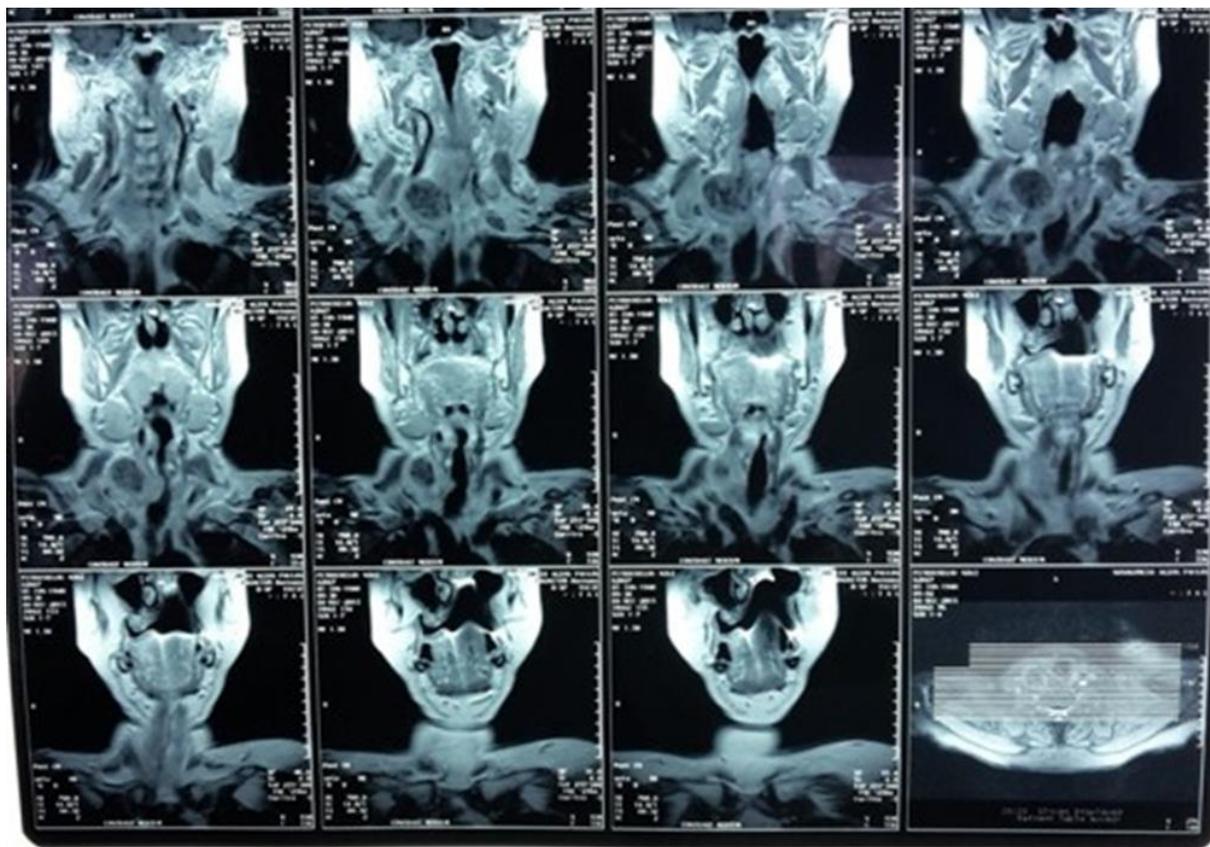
Cervix MRI-scan
